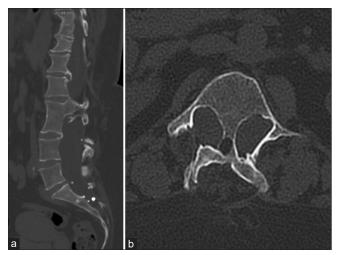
Computed tomography of the lumbar spine without contrast demonstrating the diastematomyelia and bony osseous bar at L1 to L2 levels (a: Sagittal view; b: Axial view).
